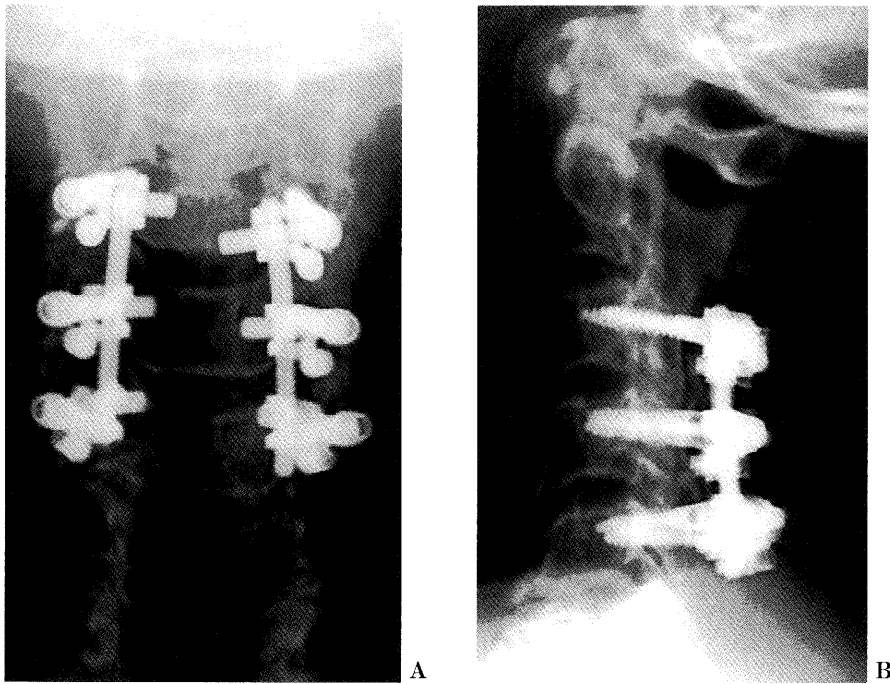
X-rays after the second operation of multi-segmental fusion from C3 to C5 using a pedicle screw system with the neck in extension. Posteroanterior A. and lateral B. views.
